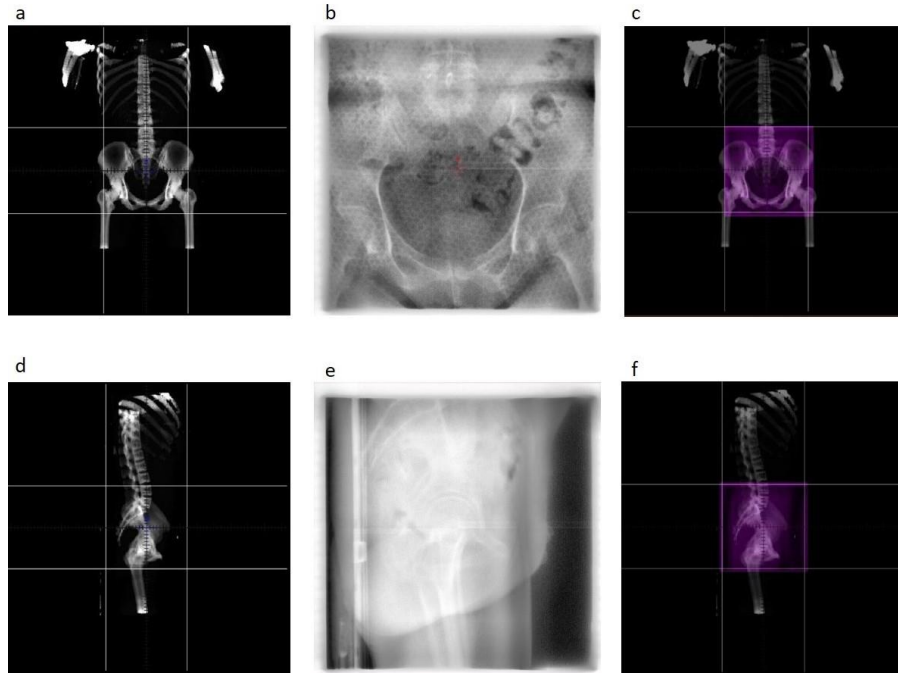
Offline setup verification using MOSAIQ software; (a) Anterior-posterior Digitally Reconstructed Radiograph (DRR), (b) Anterior-posterior EPID, (c) Anterior-posterior registration of the DRR and EPID to obtain deviation, (d) Lateral DRR, (e) Lateral EPID, (f) Lateral registration of the DRR and EPID.
